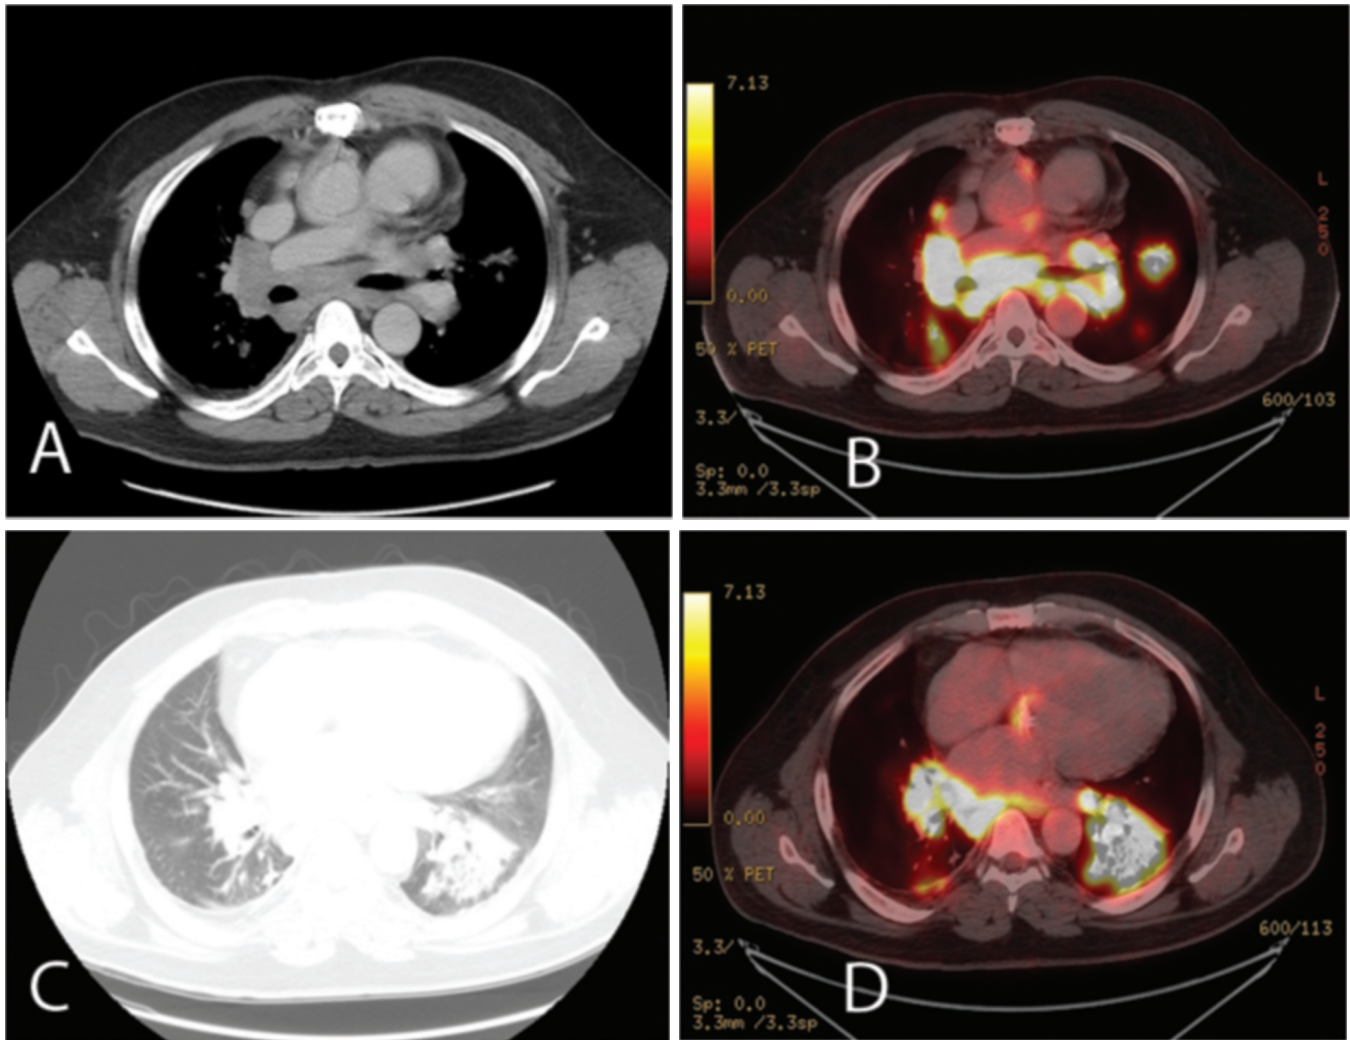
42-year-old male with sarcoidosis. Select axial ^{18}F -FDG PET/CT images of the chest demonstrate multiple large, hypermetabolic mediastinal and bilateral hilar lymph nodes (A and B). There is also hypermetabolic activity within bilateral lower lobes (D) corresponding to airspace consolidation in the left lower lobe and irregular thickening of bronchovascular bundles. Nodularity along the fissures appears mainly in the right lower lobe (C).
